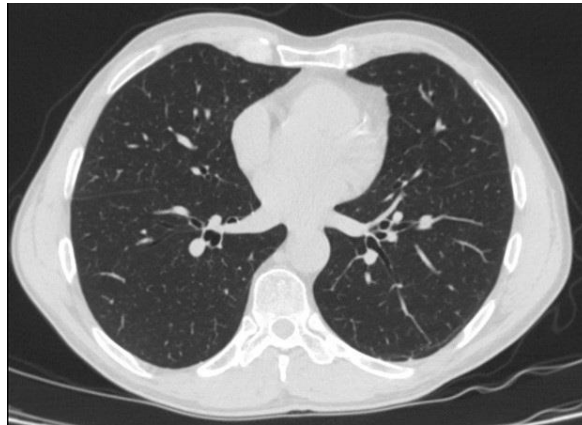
Representative view from computed tomography (CT) scan (axial plane) showing clear lungs.
